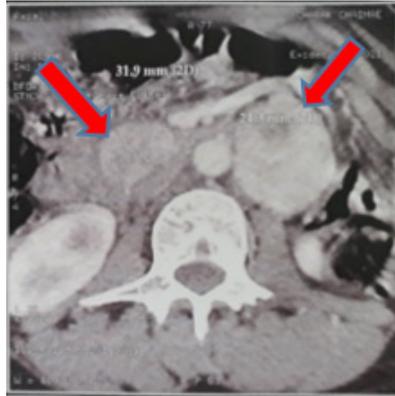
Retroperitoneal paragangliomas on CT scan.
